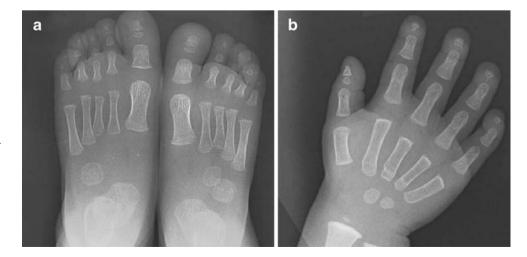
Skeletal survey radiographs at 20 months demonstrate stippled calcifications in the soft tissues surrounding the (a) tarsal bones and distal phalanges of the feet as well as (b) shortening of the second and third metacarpals and distal phalanges. Epiphyses are generally normal in appearance in this patient with none of the blotchy stippling noted in some chondrodysplasia punctata subtypes
